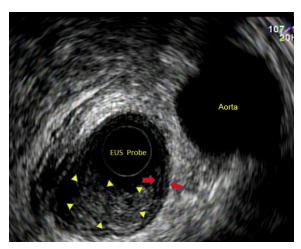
Endoscopic Ultrasound image showing non circumferential hypoechoic esophageal mass (yellow arrowheads) confined to the mucosa with a well preserved esophageal wall architecture (in between the red arrows). Image courtesy of the University of Massachusetts Medical School, Department of Medicine, Division of Gastroenterology.
